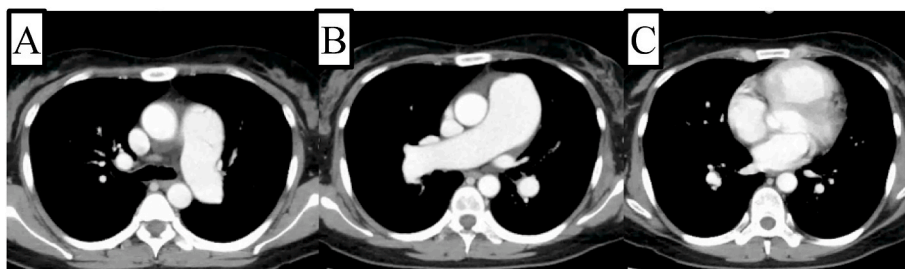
Contrast enhanced computed tomography images on admission of upper field (A), middle field (B), and lower field (C).
